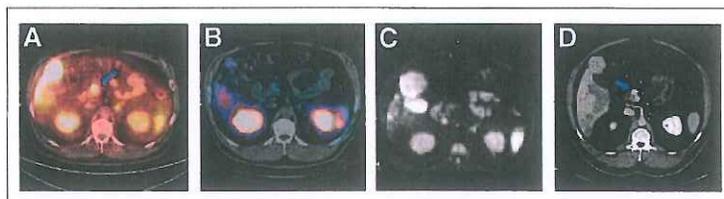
A 49-y-old man with NET of unknown origin for over 4 y. ^{68}Ga -DOTATATE PET/CT (A) identified primary pancreatic lesion (arrow), whereas SSRS SPECT/CT (B) and WB DWI (C) did not. This lesion was noted only retrospectively (arrow) on dedicated abdominal CT (D) performed 4 y previously.
